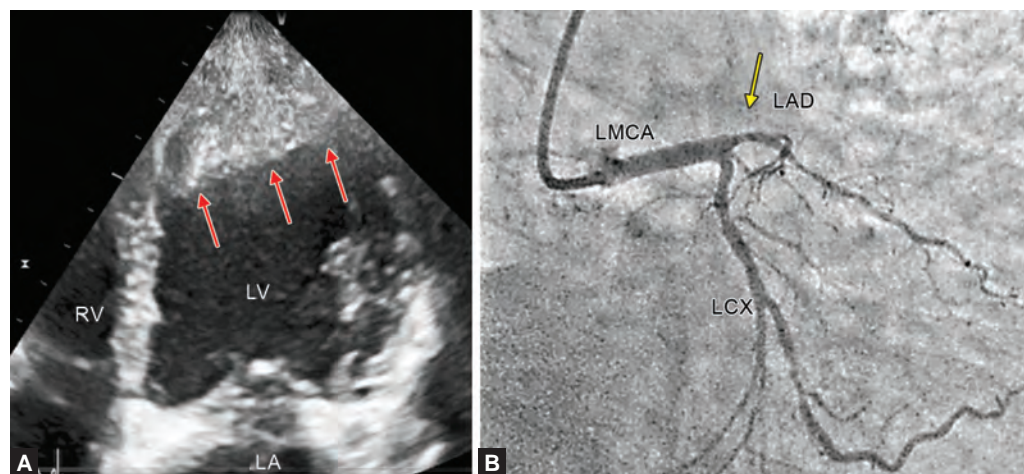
AND B: A 67-year-old diabetic male patient with ongoing chest pain with acute anterior myocardial infarction. Coronary angiogram (in inset) reveals 75% stenosis in the middle of the left anterior descending artery with good epicardial flow. Echocardiographic apical four-chamber view shows echolucent thickening of the mid- and apical septum (red arrows).
